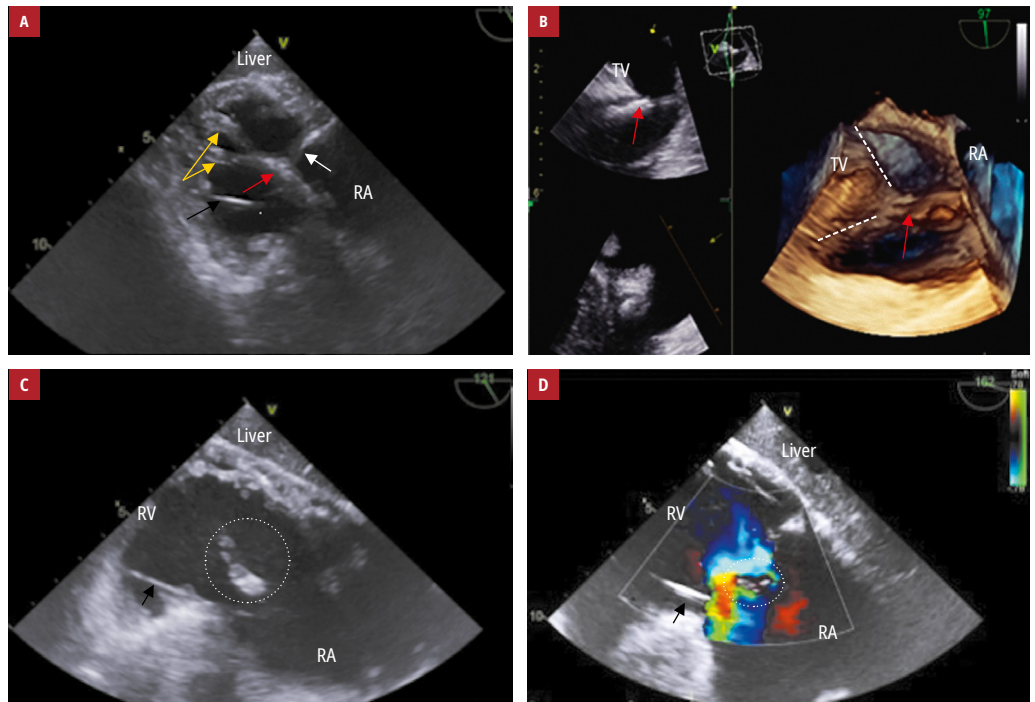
Tricuspid valve damage during transvenous lead extraction: A – transesophageal echocardiography (TEE; 2-dimensional, transgastric view) showing lead adhesion (red arrow) to the posterior leaflet (white arrow) and the subvalvular apparatus (yellow arrows) detected during lead extraction. Black arrows mark the lead for temporary pacing. B – TEE (3-dimensional, transgastric view from the right atrial side) showing pulling on the lead (red arrows) and the tricuspid valve (white arrows indicate the leaflets and the annulus); C – TEE (2-dimensional, transgastric view) showing a ruptured papillary muscle head prolapsing into the right heart chambers (white circle), D – TEE (2-dimensional, transgastric view) with color Doppler imaging showing the significant regurgitant jet extending into the right atrium and a fragment of the detached papillary muscle moving into the tricuspid ostium
